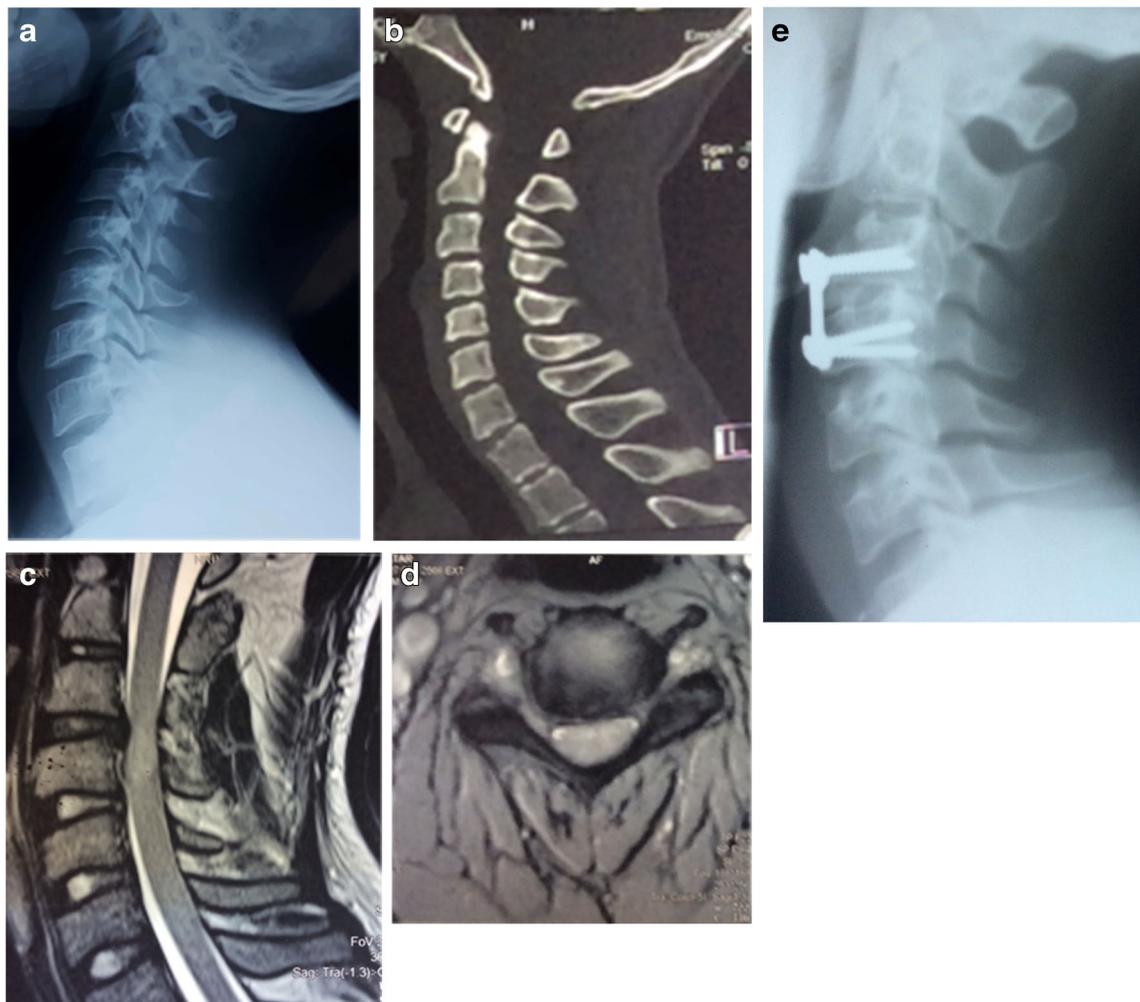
Images of a 23-year-old patient, victim of contact sport (wrestling) accident, ASIA's grade C without bony injuries on both lateral X-ray (a) and CT scan (b). Pre-operative MRI images. Left: sagittal T2-weighted MRI image (c) showing severely compressed spinal cord at C3-C4 level. Right: axial T2-weighted MRI image (d) showing cervical disc herniation
